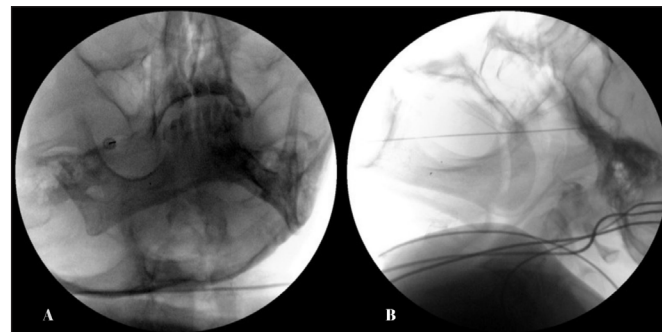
Placement of the radiofrequency needle in oblique submental (A) and lateral (B) cranial radiograph images.
